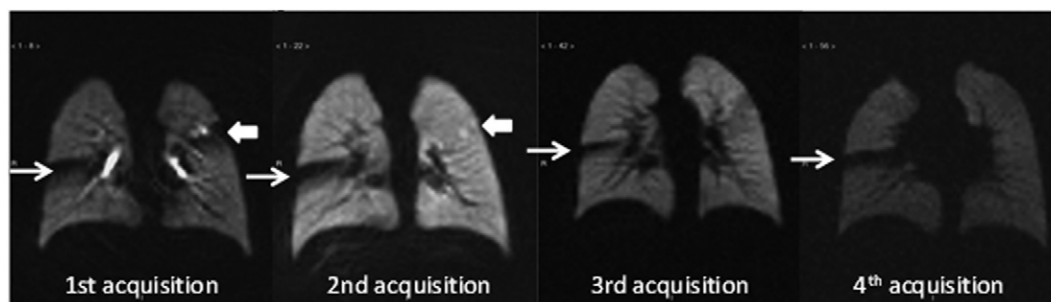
Coronal HHe MRI slice sections obtained at the same anatomic level in a non-sedated, unrestrained 3-year-old child with asthma breathing gas from a bag containing HHe. On the first acquisition, ventilation defects are present in the right lower lobe (thin arrows) and the left upper lobe (thick arrows). With successive breaths, the left upper lobe defect fills in (thick arrows), but the right lower lobe defect does not (thin arrows).
